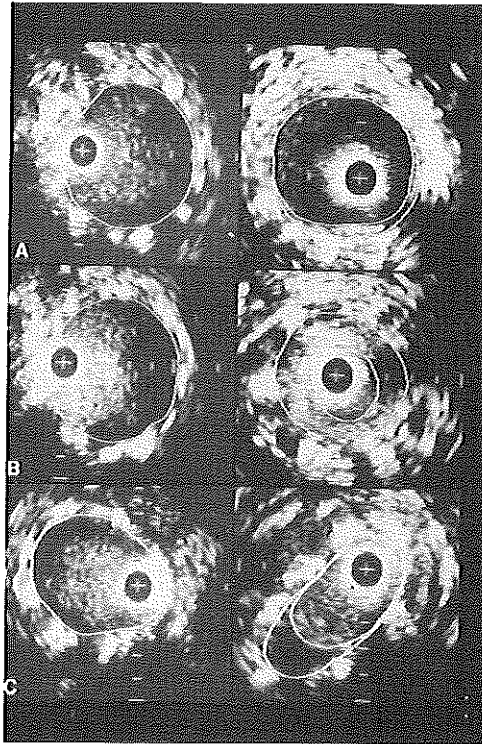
Matched intravascular ultrasound cross-sections of the femoropopliteal artery obtained after stent deployment (left panels) and at 5 months follow-up (right panels). The lumen area (inner contour) and stent area (outer contour) display the quantitative results. A, In-stent changes were minimal. B, Intimal hyperplasia and stent area reduction (remodeling) were the predominant mechanisms responsible for restenosis seen at the stent junctions. C, Distally remodeling of the stent in the region of the adductor canal hiatus. + = catheter; calibration = 1 mm.
